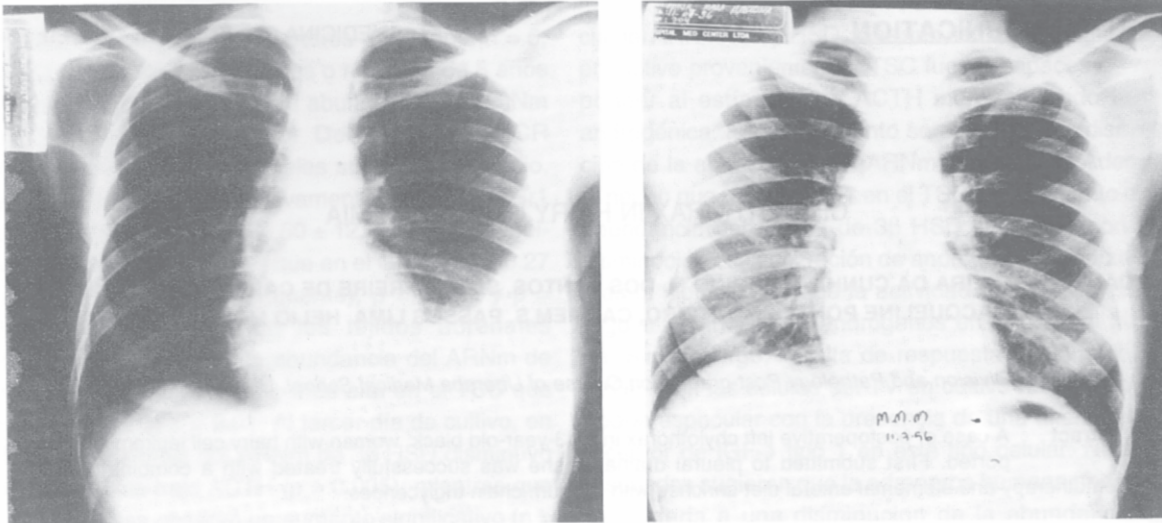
Thorax radiography in 05/29/96: voluminous left pleural effusion (A). Control in 06/11/96: absence of pleural effusion (B).
